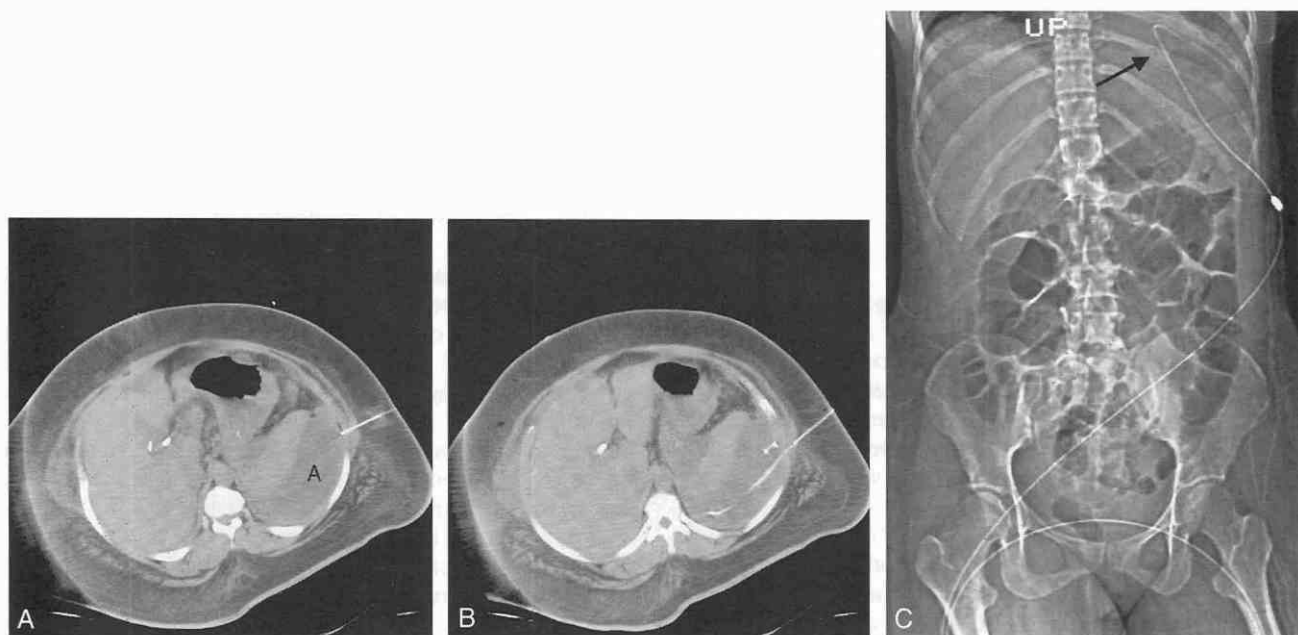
A, CT scan shows fluid collection around the spleen. The needle is directed posteriorly and cephalad. B, With insertion of wire, the wire moves posterior and cephalad. C, With a digital radiograph, the cephalad positioning of the wire at the highest level of the abscess (arrow) below the diaphragm can be appreciated. There is no need to traverse the pleura to drain these very high collections.
